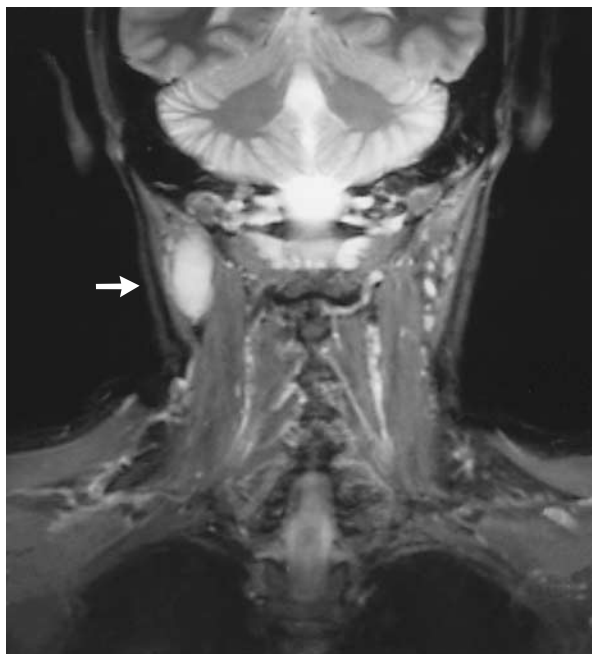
Magnetic Resonance Imaging of the Lymph-Node Mass in the Right Side of the Patient's Neck.
